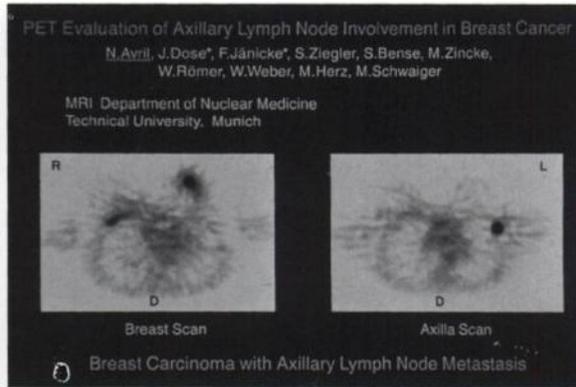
Researchers used ^{18}F FDG to search the axillary lymph nodes for metastases in patients with breast cancer.
